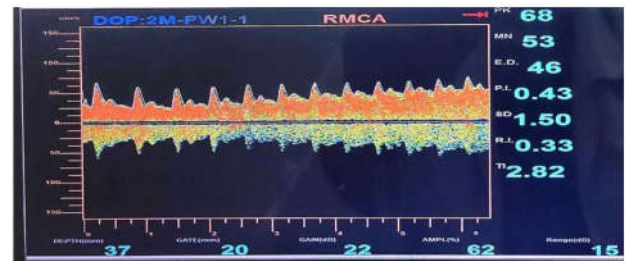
Recording of the Transcranial Doppler
